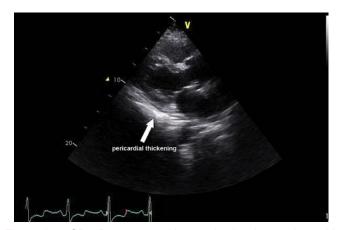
CP: 2D parasternal long-axis view in a patient with CP (Video A6). The *arrow* points to a focal region of pericardial calcification extending from the atrioventricular groove to the posterior LV wall. This finding, in conjunction with an interventricular septal bounce, is consistent with CP.
